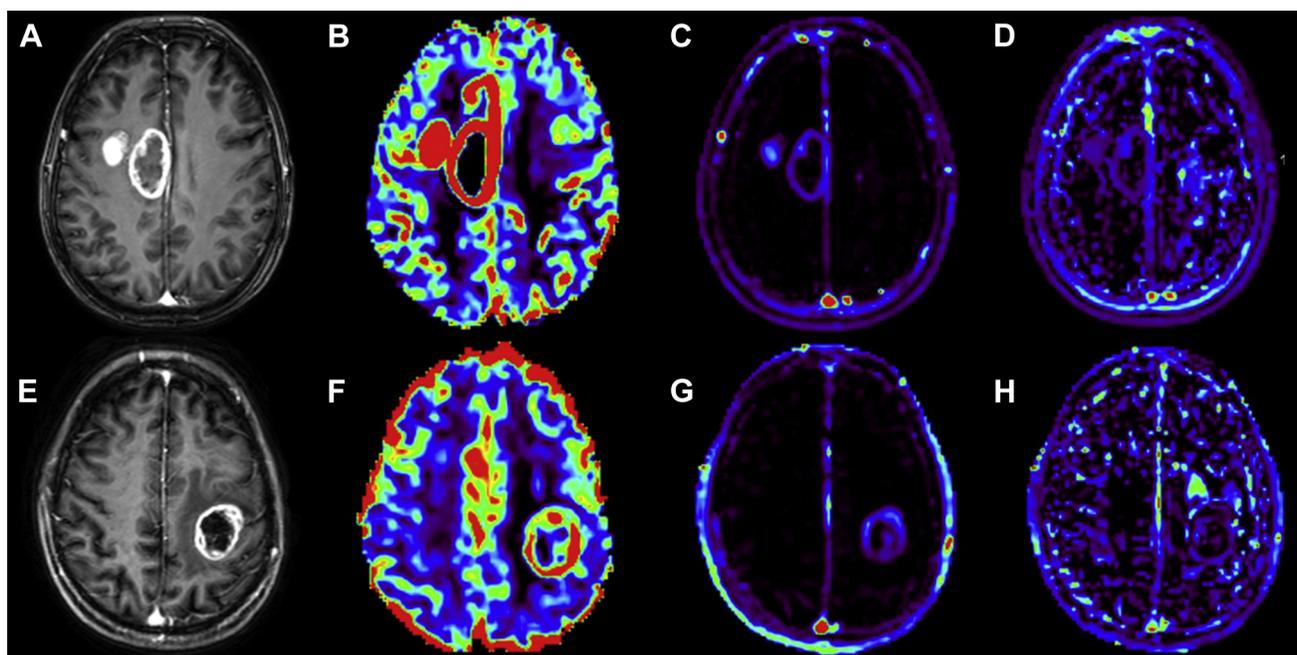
Images from patients with glioblastoma with high and a low plasma von Willebrand factor:Ag levels. (A, E) T1-weighted imaging postcontrast, (B, F) relative cerebral blood volume maps, (C, G) volume
